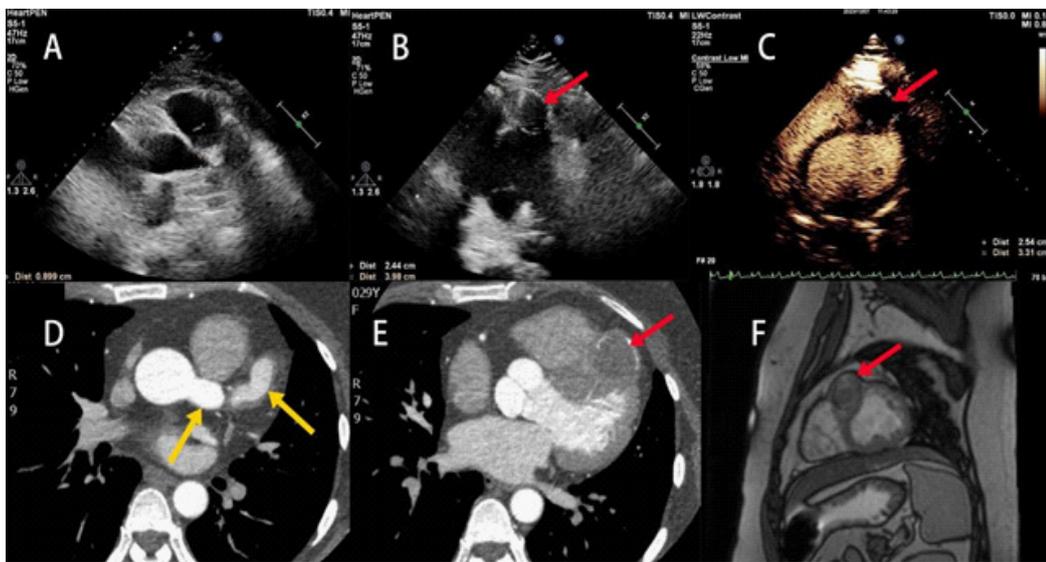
(A) Echocardiography revealed a dilated blood vessel on the left side of the aortic root; (B) A localized low-echo bulge was observed in the front of middle segment of the anterior interventricular septum; (C) MCE A well-defined low-echo area was detected in front of the interventricular groove; (D) Coronary CTA showed the left main coronary artery and the proximal left anterior descending artery were dilated; (E) A middle segment was dilated to aneurysm with the widest diameter about 32 mm × 31 mm; (F) CMR The proximal luminal signal was similar to that of the blood pool, and there is a mixture of high and low T2 signals in the distal cavity.
